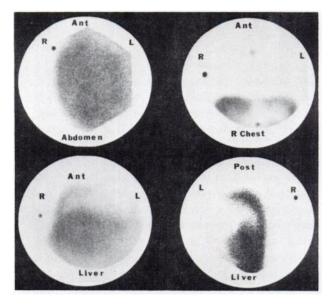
(Upper left) Anterior abdominal scintigram at 30 min reveals well-distributed tracer throughout peritoneal cavity. (Upper right) Anterior chest view at 1 hr fails to show any tracer in chest tubing or in pulmonary and cardiac blood pools. (Lower left and right) Anterior and posterior scintigrams of upper abdomen indicate total absence of tracer in liver, causing it to appear as void surrounded by ascitic radioactivity. Dark spot at margin is source marking patient's right side. Additional dark spots in upper right scintigram mark suprasternal notch and xiphoid process.
